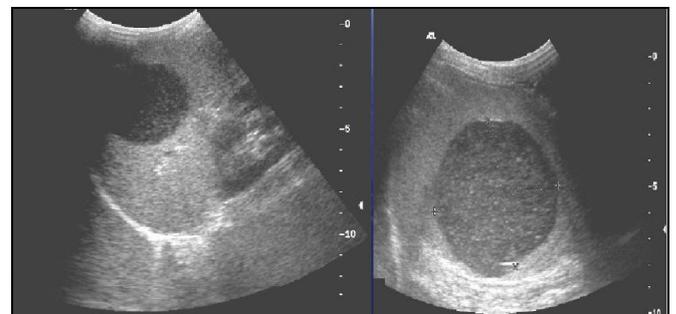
Ultrasound image showing a thin walled hypoechoic formation.
